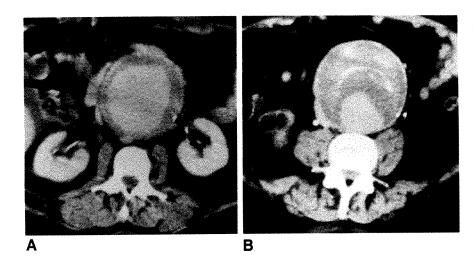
A and B, Postinfusion CT scans. Opacified abdominal aortic aneurysm lined with low-attenuation thrombus. Note that thrombus is partially calcified.
